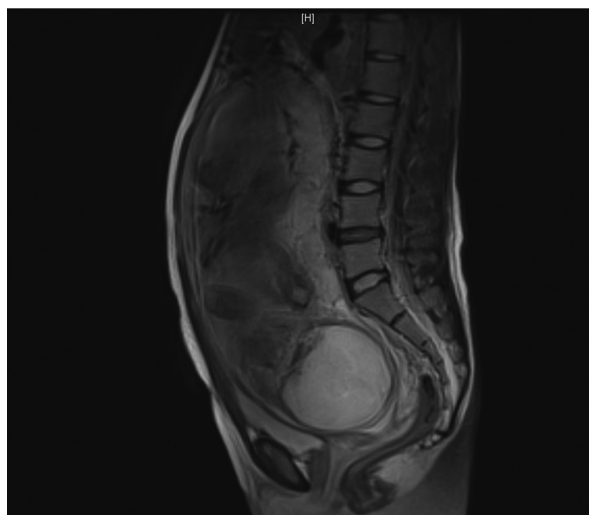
Sagittal T2-weighted MRI at 30 weeks showed no evidence of placenta previa, and the placenta was mainly located on the posterior wall (T2).
